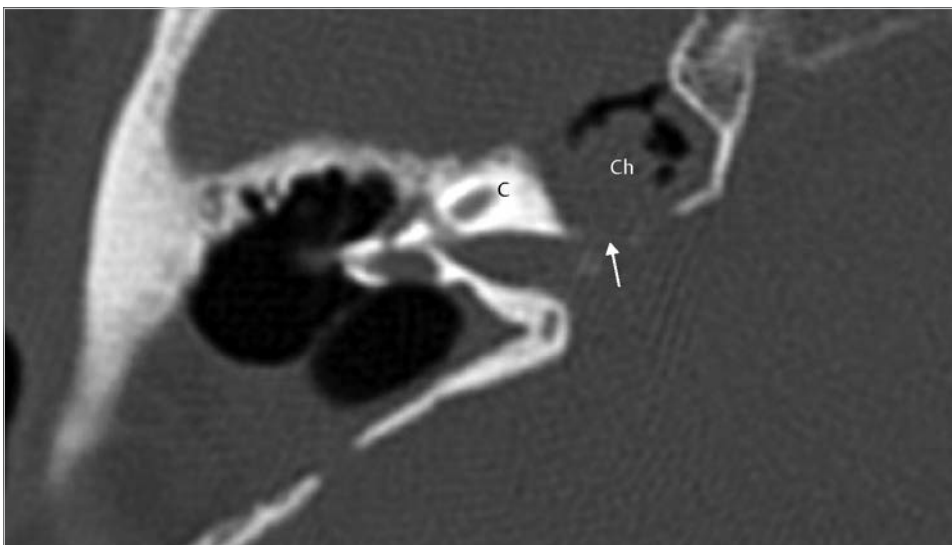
The patient underwent surgery elsewhere 6 years before visiting our office. The external auditory canal has been closed, and the cavity is filled with abdominal fat. A dead ear with facial weakness resulted. The axial CT at the level of the labyrinthine segment of the facial nerve shows recurrence of cholesteatoma in the petrous apex to erode the internal auditory canal (arrow). C, cochlea; Ch, cholesteatoma.
